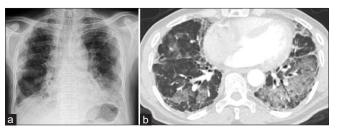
(a) Bilateral infiltration on chest X-ray. (b) Thorax computed tomography showing bilateral widespread ground-glass opacities and interlobular and intralobular septal thickening
